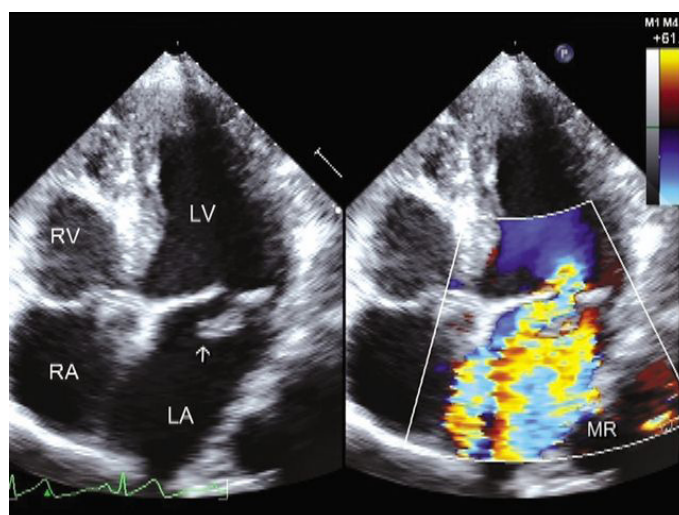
Two-dimensional transthoracic echocardiography demonstrates a myxomatous mitral valve and prolapse of posterior mitral leaflet (arrow) with severe MR. RV: right ventricle; RA: right atrium; LV: left ventricle; LA: left atrium; MR: mitral regurgitation. Reproduced with permission from Manjunath *et al.*^[4]
